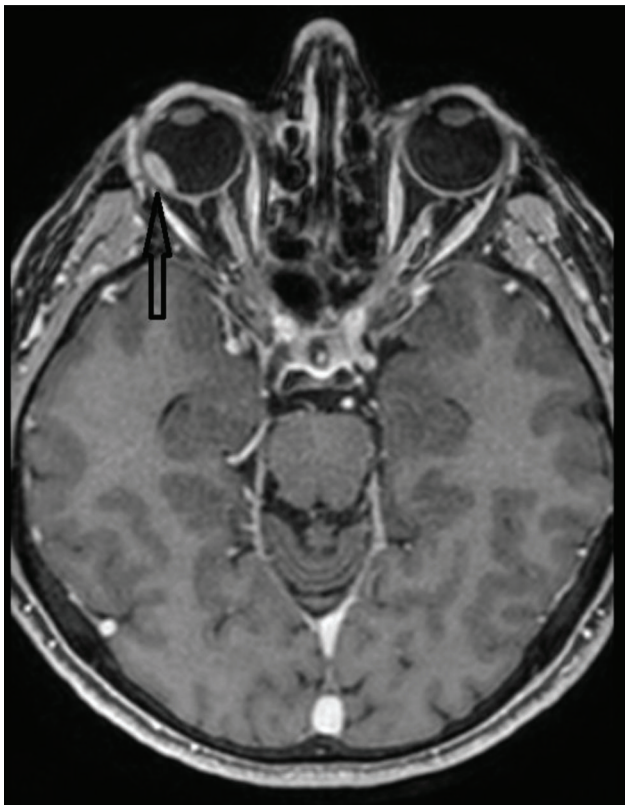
The head MRI scan. Contrast-enhanced flat mass in the lateral part of the right eyeball (arrow) on the T1 post-contrast image.
